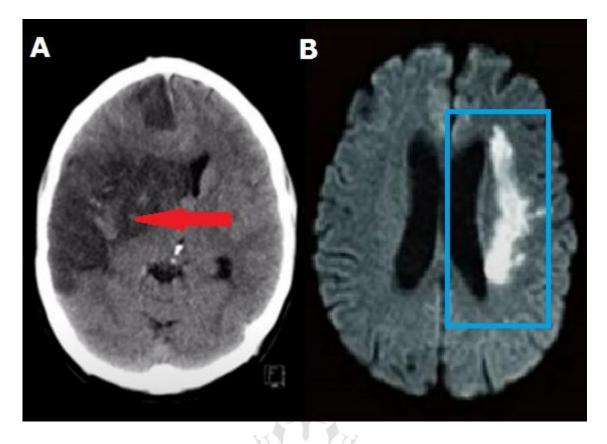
Brain computed tomography of one of our patients who underwent cardiac surgery; diffuse embolic infarct view in the right hemisphere (red arrow) (A); Ischemic changes around the left ventricle in the dynamic magnetic resonance image of another operated patient (blue frame) (B).
